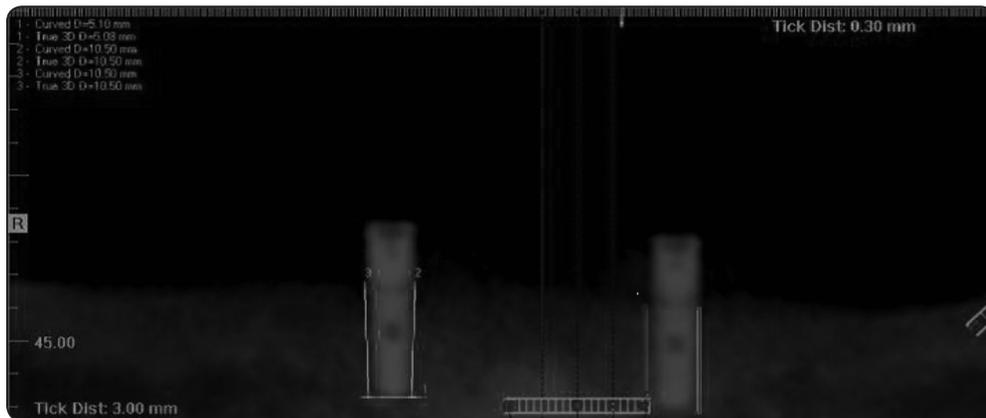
Radiographic Evaluation of crestal bone loss around implants
